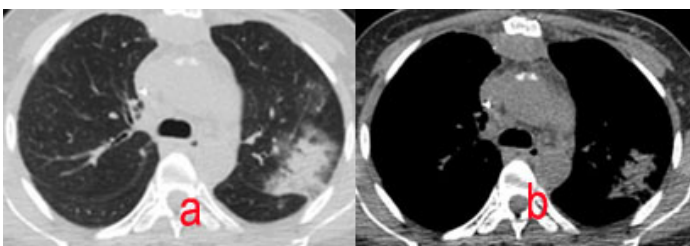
(a,b): Thoracic CT revealed consolidated area in the posterior segment of the left upper lobe.
